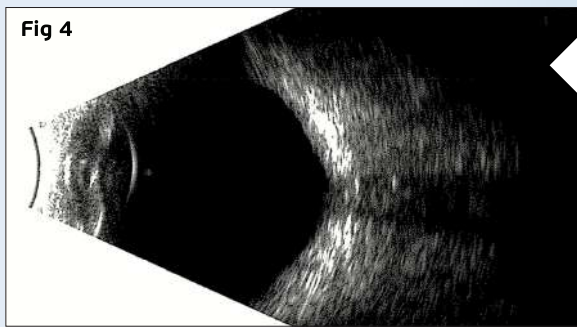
B-mode ultrasonography of the RE showing no evidence of calcification at the optic papilla.
